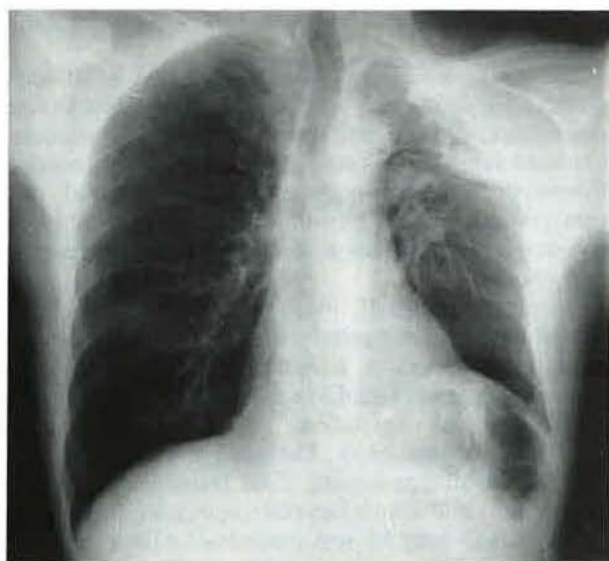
Chest X-ray six months later: the fungus ball is diminished in size. Also the cavitory lesion becomes smaller and is surrounded by fibrotic reaction due to previous radiotherapy.
